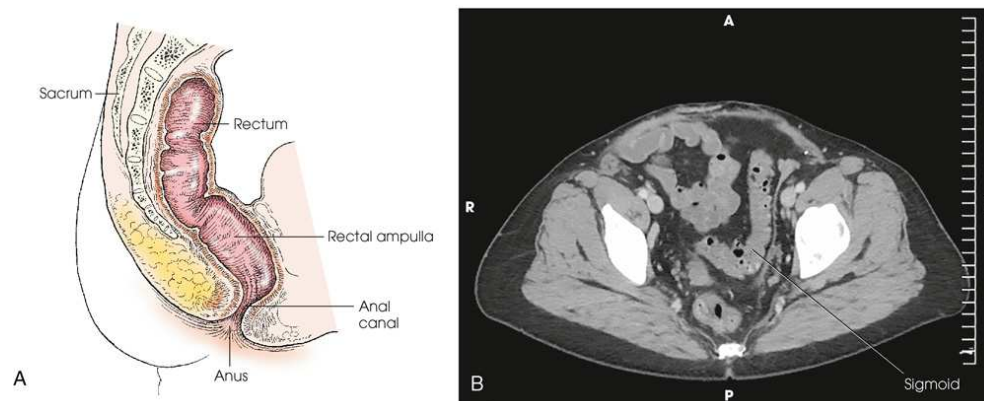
(A) Sagittal section showing direction of anal canal and rectum. (B) Axial CT image of lower pelvis showing rectum and sigmoid colon in relation to surrounding organs. B, Courtesy Aimee Rowlett, RT[R] [CT], NEA Baptist Memorial Hospital, Jonesboro, AR.
